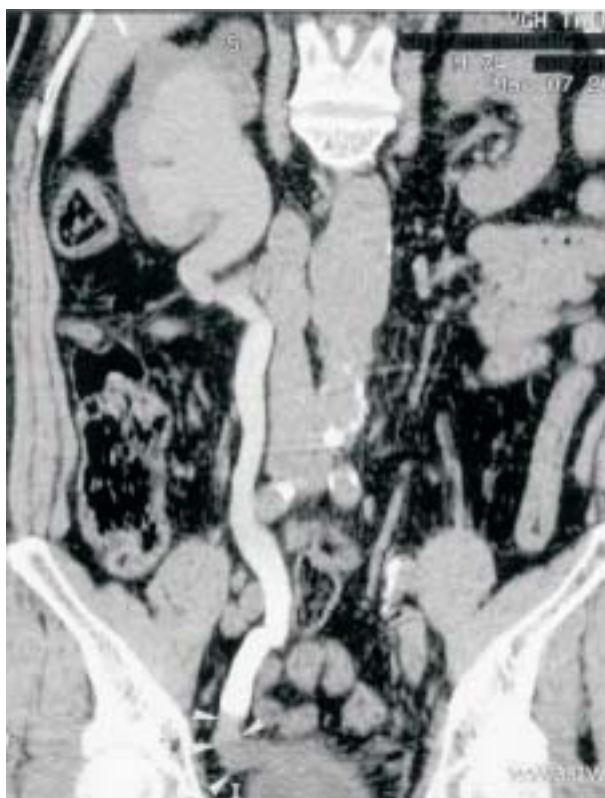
A 74-year-old man with gross hematuria for 1 week. The CT urography was performed after retrograde pyelography. It shows marked right hydronephrosis and hydroureter caused by soft tissue density (arrowheads) at the right distal ureter. The CT urographic findings suggest right distal ureter neoplasm. However, the result of biopsy showed only some inflammatory cells infiltration.
